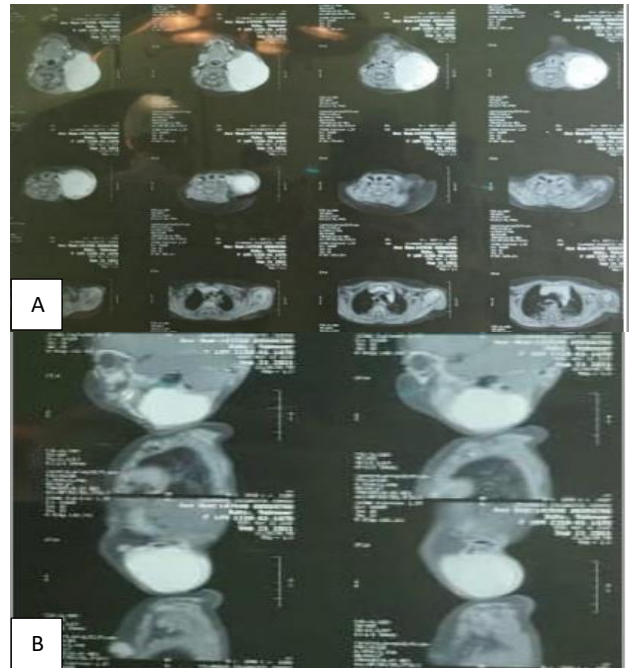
(A and B): MRI of the neck with splaying of the carotid sheath, however, deep to the sternocleidomastoid.
